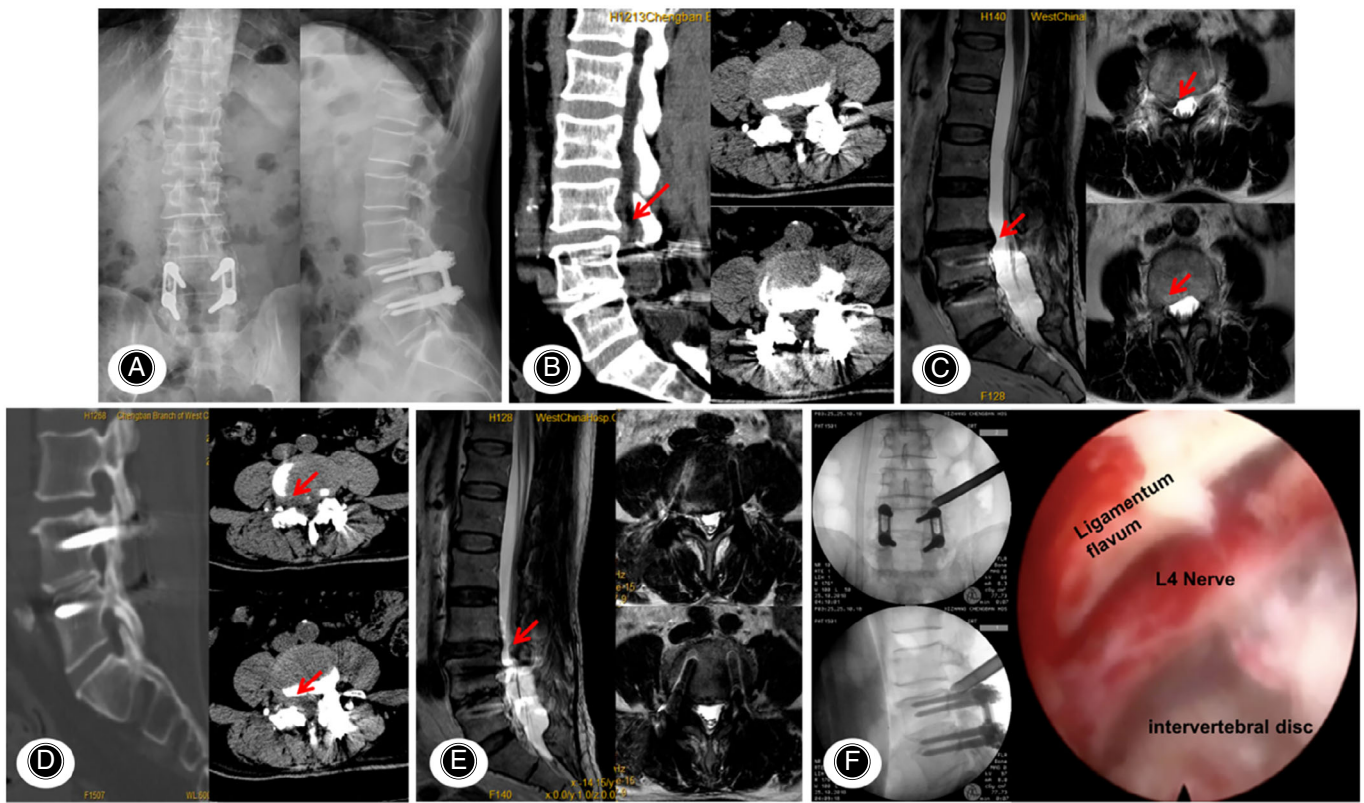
A 61-year-old man with symptomatic ASD who underwent PELD. (A) Preoperative anterior and lateral X-rays showed that the lumbar 4/5 had previously undergone PLIF surgery; (B, C) Preoperative CT and MRI showed herniation of the intervertebral disc in the right of adjacent lumbar 3/4 segment (red arrow); (D, E) Postoperative CT and MRI showed that the herniated intervertebral disc on the right side of the lumbar 3/4 had been removed (red arrow); (F) Intraoperative fluoroscopy showing the placement of the protective sleeve and L4 nerve root after decompression
